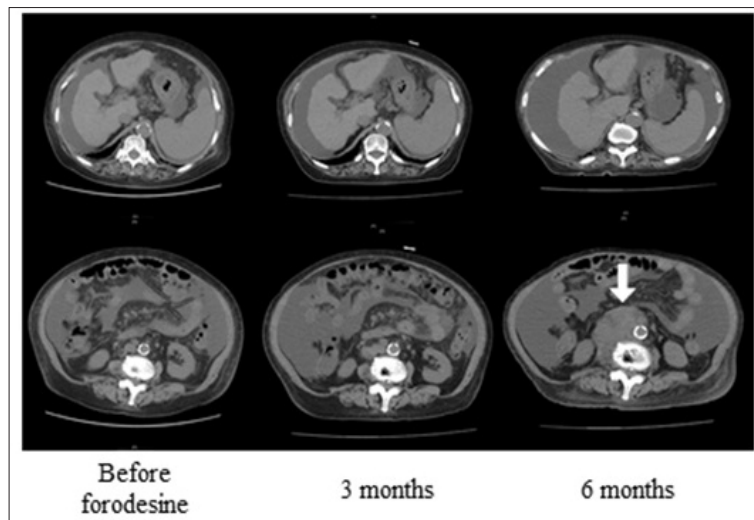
Computed tomography (CT) of the abdomen. Hepatatrophia, ascites and splenomegaly were confirmed, reflecting liver cirrhosis. Forodesine maintained stable disease for 3 months, with progression at 6 months (arrow).*
